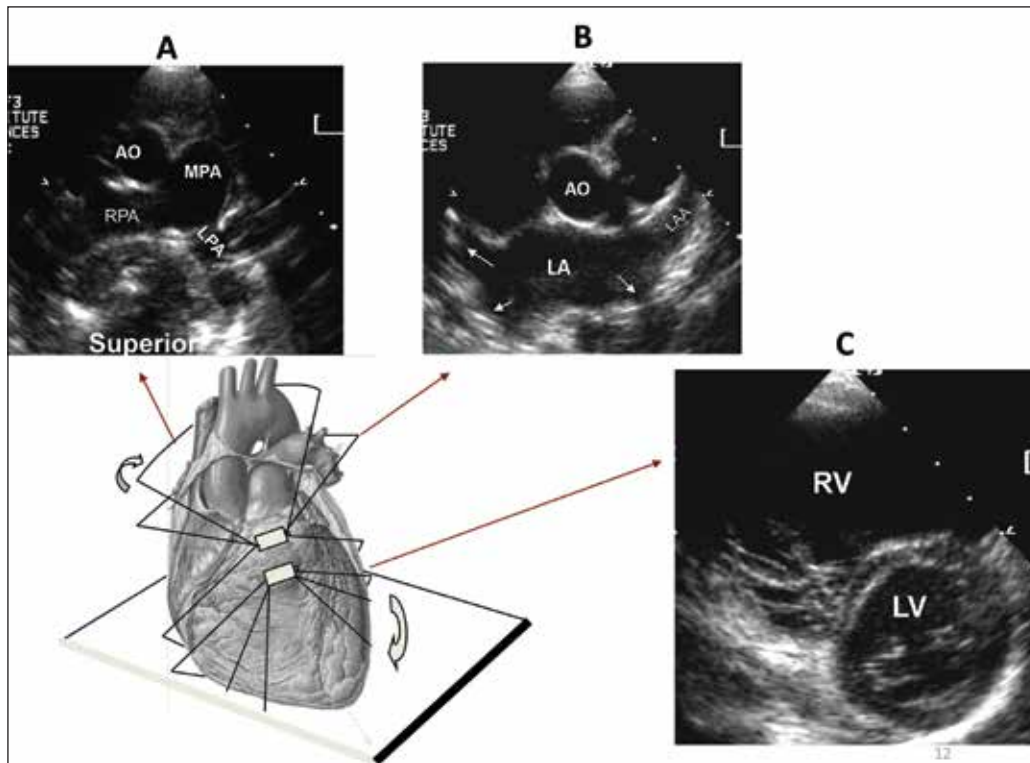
Transducer position and imaging planes for the parasternal short-axis views. Superior sweep (A) enables visualization of the branch pulmonary arteries (RPA and LPA), the main pulmonary artery (MPA) is seen to the left of the aorta (Ao). B. Shows images obtained using a slight downward tilt of the transducer in the parasternal short axis view. This enables visualization of the left atrial appendage (LAA) and the pulmonary veins (arrows). Frame C is obtained by sliding slightly downwards and pointing the transducer towards the apex. The ventricular cavity cross-section is profiled.
